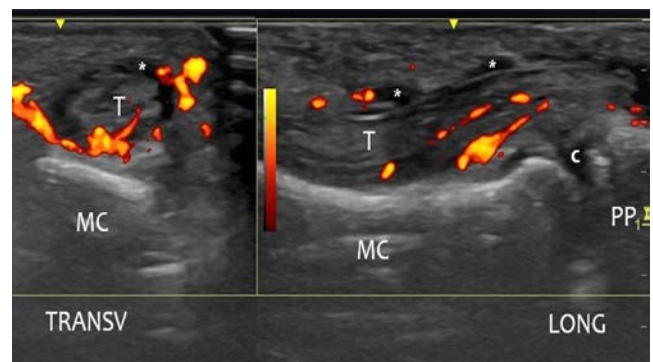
Tenosynovitis on Doppler ultrasound imaging of the finger of a 6-year-old child. The image shows the presence of tendon sheath effusion (*) and peritendinous Doppler signal within the synovial sheath in the flexor tendon of the second finger, seen in 2 perpendicular planes. c = unossified hyaline cartilage of the secondary ossification nucleus of the phalanx; MC = metacarpal bone; PP = proximal phalanx; T = tendon.
